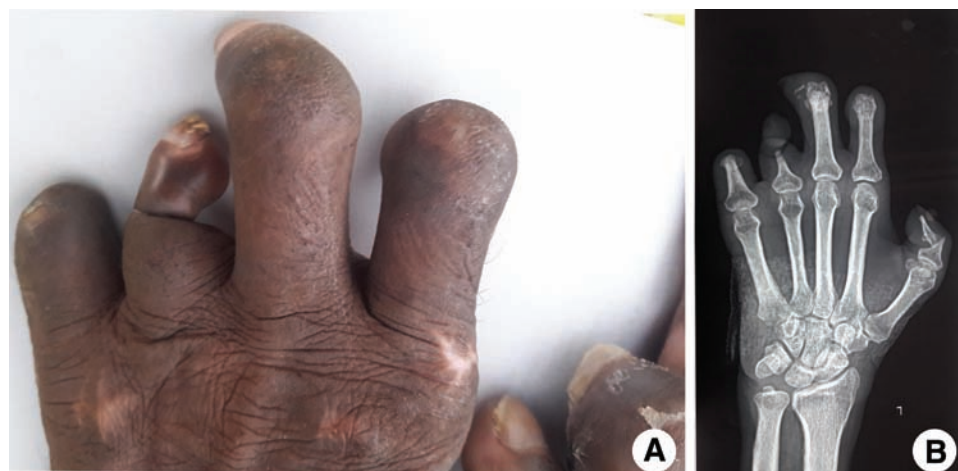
Clinical features of a patient with pseudoainhum and lepromatous leprosy. (A) Ainhum involving the fourth digit of the left hand in a patient with lepromatous leprosy. (B) Left hand X-ray image showing focal narrowing due to a fibrous band at the second interphalangeal joint with a shiny tethering distal phalanx.
